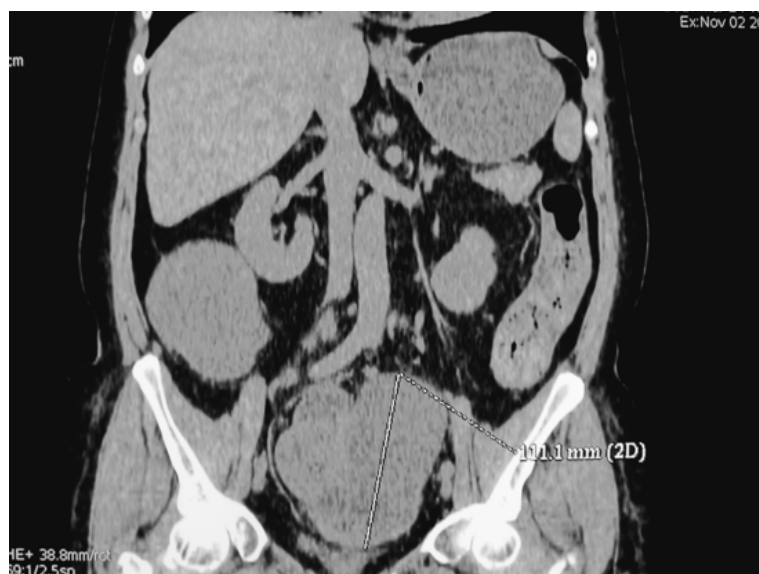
CT scan of PEComa — large pelvic and intraperitoneal tumours
